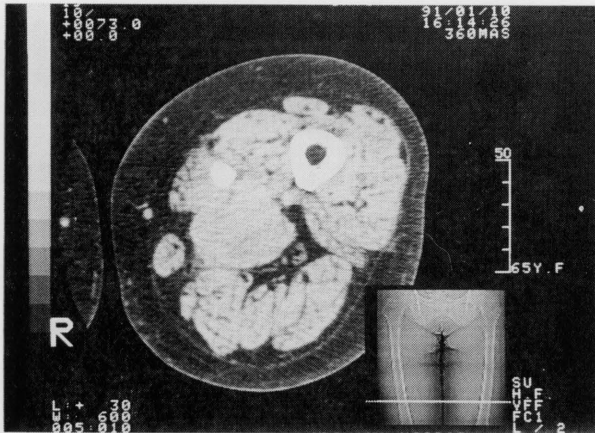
Axial computed tomography scan, 1 cm thick section, at level of the left thigh mass. The well circumscribed mass with calcification located anteromedially within the soft tissues of the thigh has an attenuation coefficient approximately equal to muscle tissue. No bony involvement is detected in the femur.
